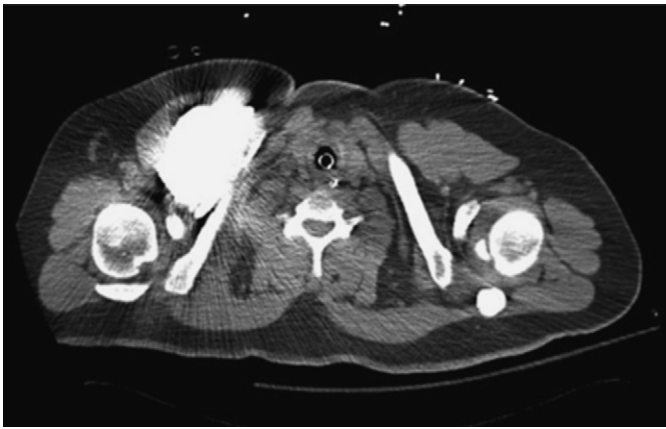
Thoracic CT scan demonstrating contrast in the right peri-clavicular space measuring 5.9 × 10.6 × 11.2 centimeters (cm).
